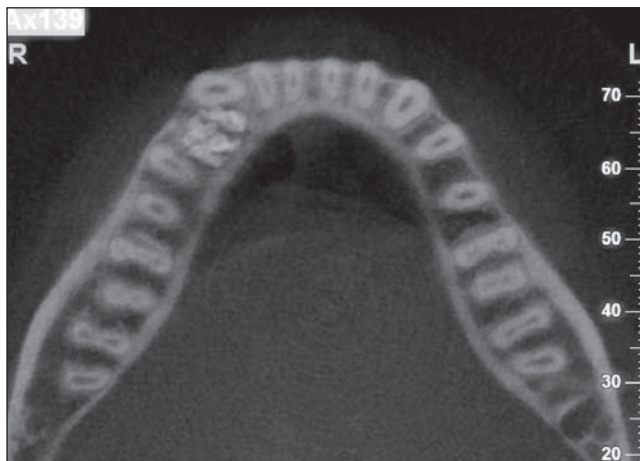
CBCT scan – compound odontoma in the area of teeth 43 and 44.
